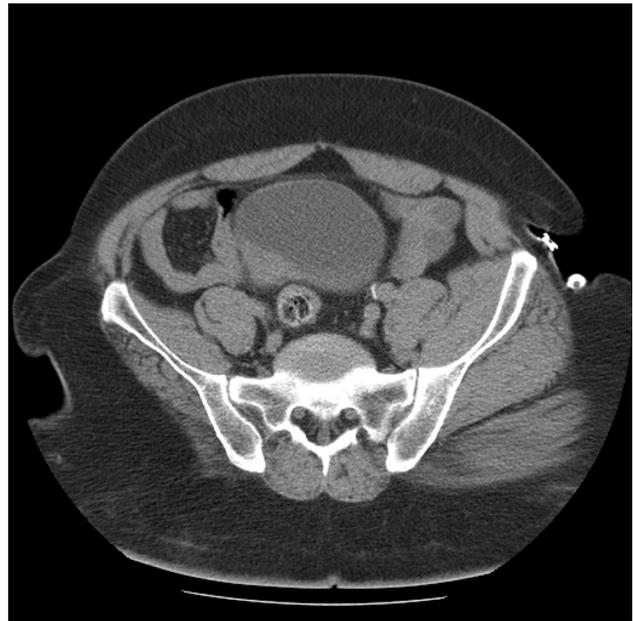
Pelvic computed tomography scan showing enhancing bladder mass in the right posterior wall of the urinary bladder
